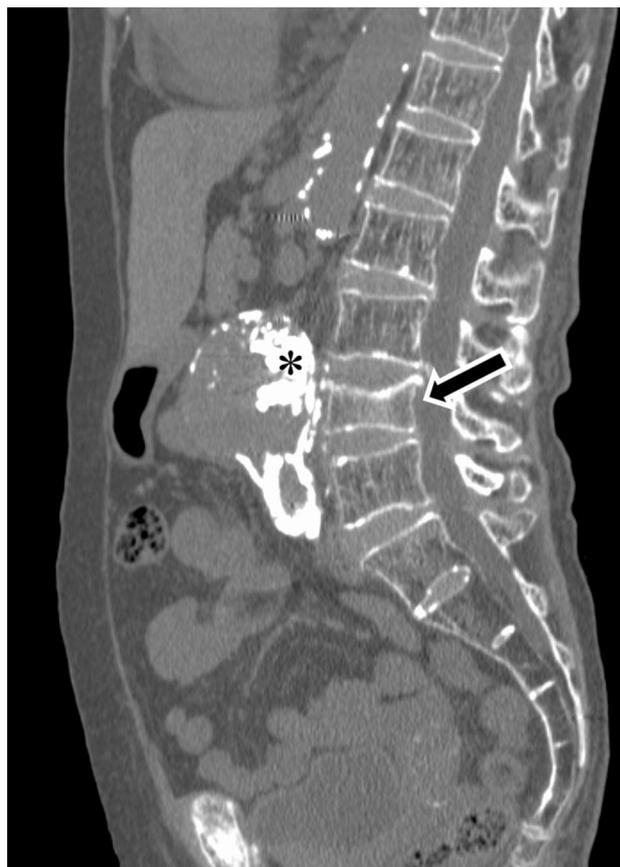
Computed tomography sagittal image acquired 12 days after treatment. Computed tomography reveals shortening of the fourth lumbar vertebra (arrow). Lipiodol remains in the aneurysmal sac (asterisk)
